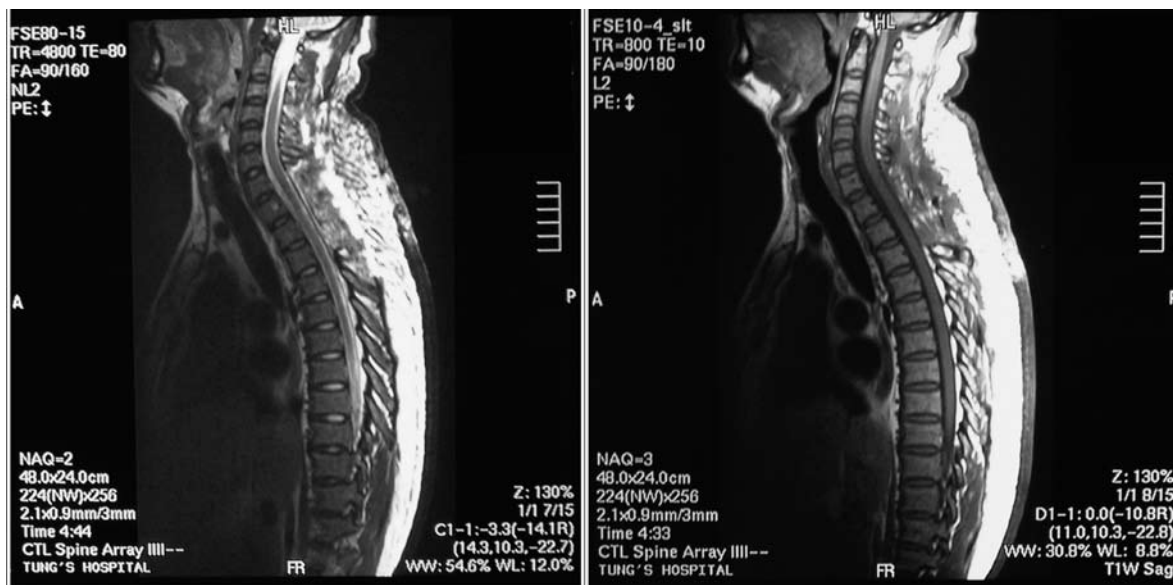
MRI examination of the patient after surgery revealed no spinal cord tumor
